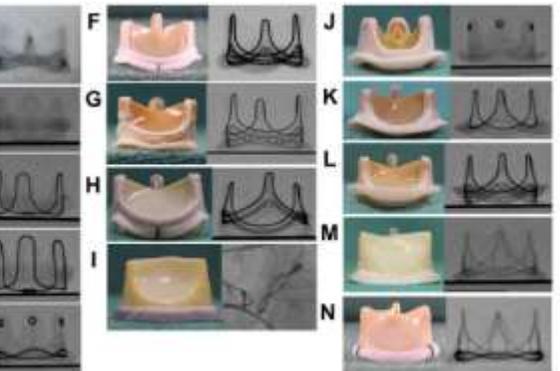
Images of commonly used surgical aortic valves (SAV) and respective echocardiographic views.
